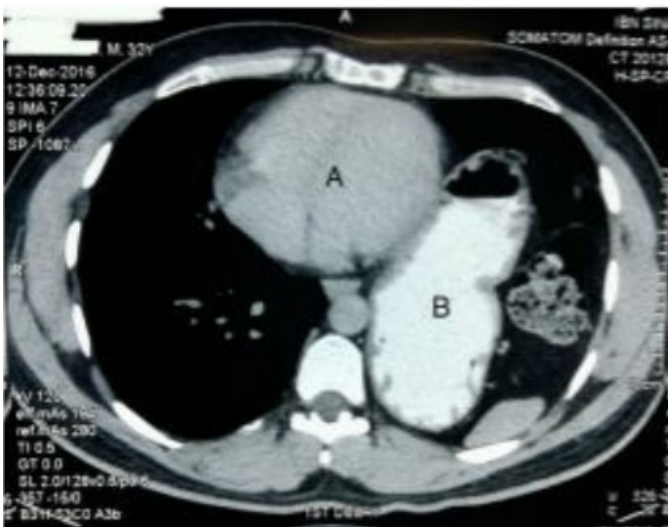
Contrast CT scan, transverse section showing the stomach (B) located within the chest cavity just beside the heart (A).
